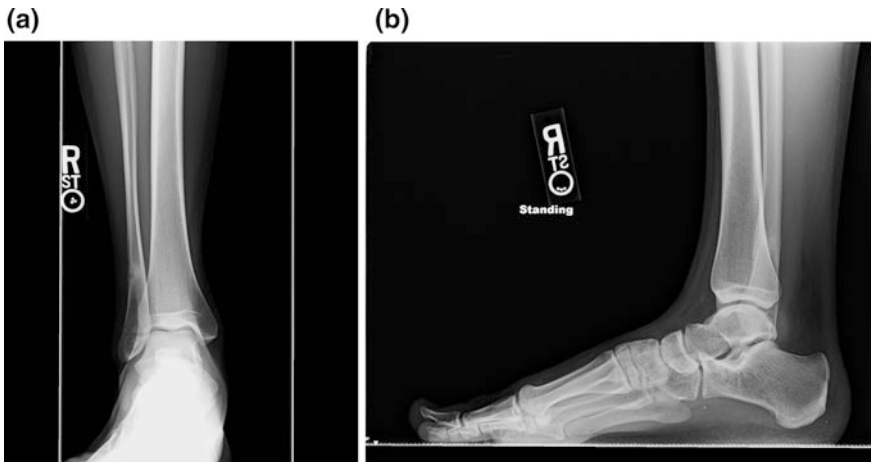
a Anteroposterior radiograph of healing right fibula stress fracture in 14-year-old female elite ballet dancer who developed ankle pain week 5 of a 6-week summer dance intensive program. b Lateral radiograph of the same healing right fibula stress fracture. The dancer was able to walk without pain after a total of 3 weeks in a removable boot and was allowed to weight-bear in sneakers and start pool, Pilates, and elliptical trainer exercises. Graduated return to full dance activities was begun after additional 3 weeks when radiographs demonstrated further healing
